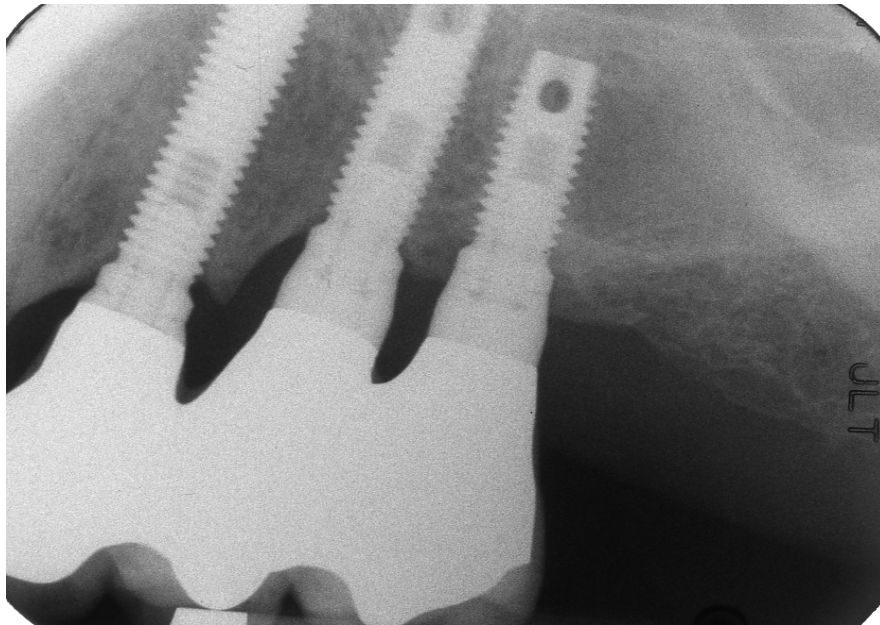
Follow-up periapical radiograph. Please notice the bone level around the second most distal left implant. The bone loss does not involve implants threads
